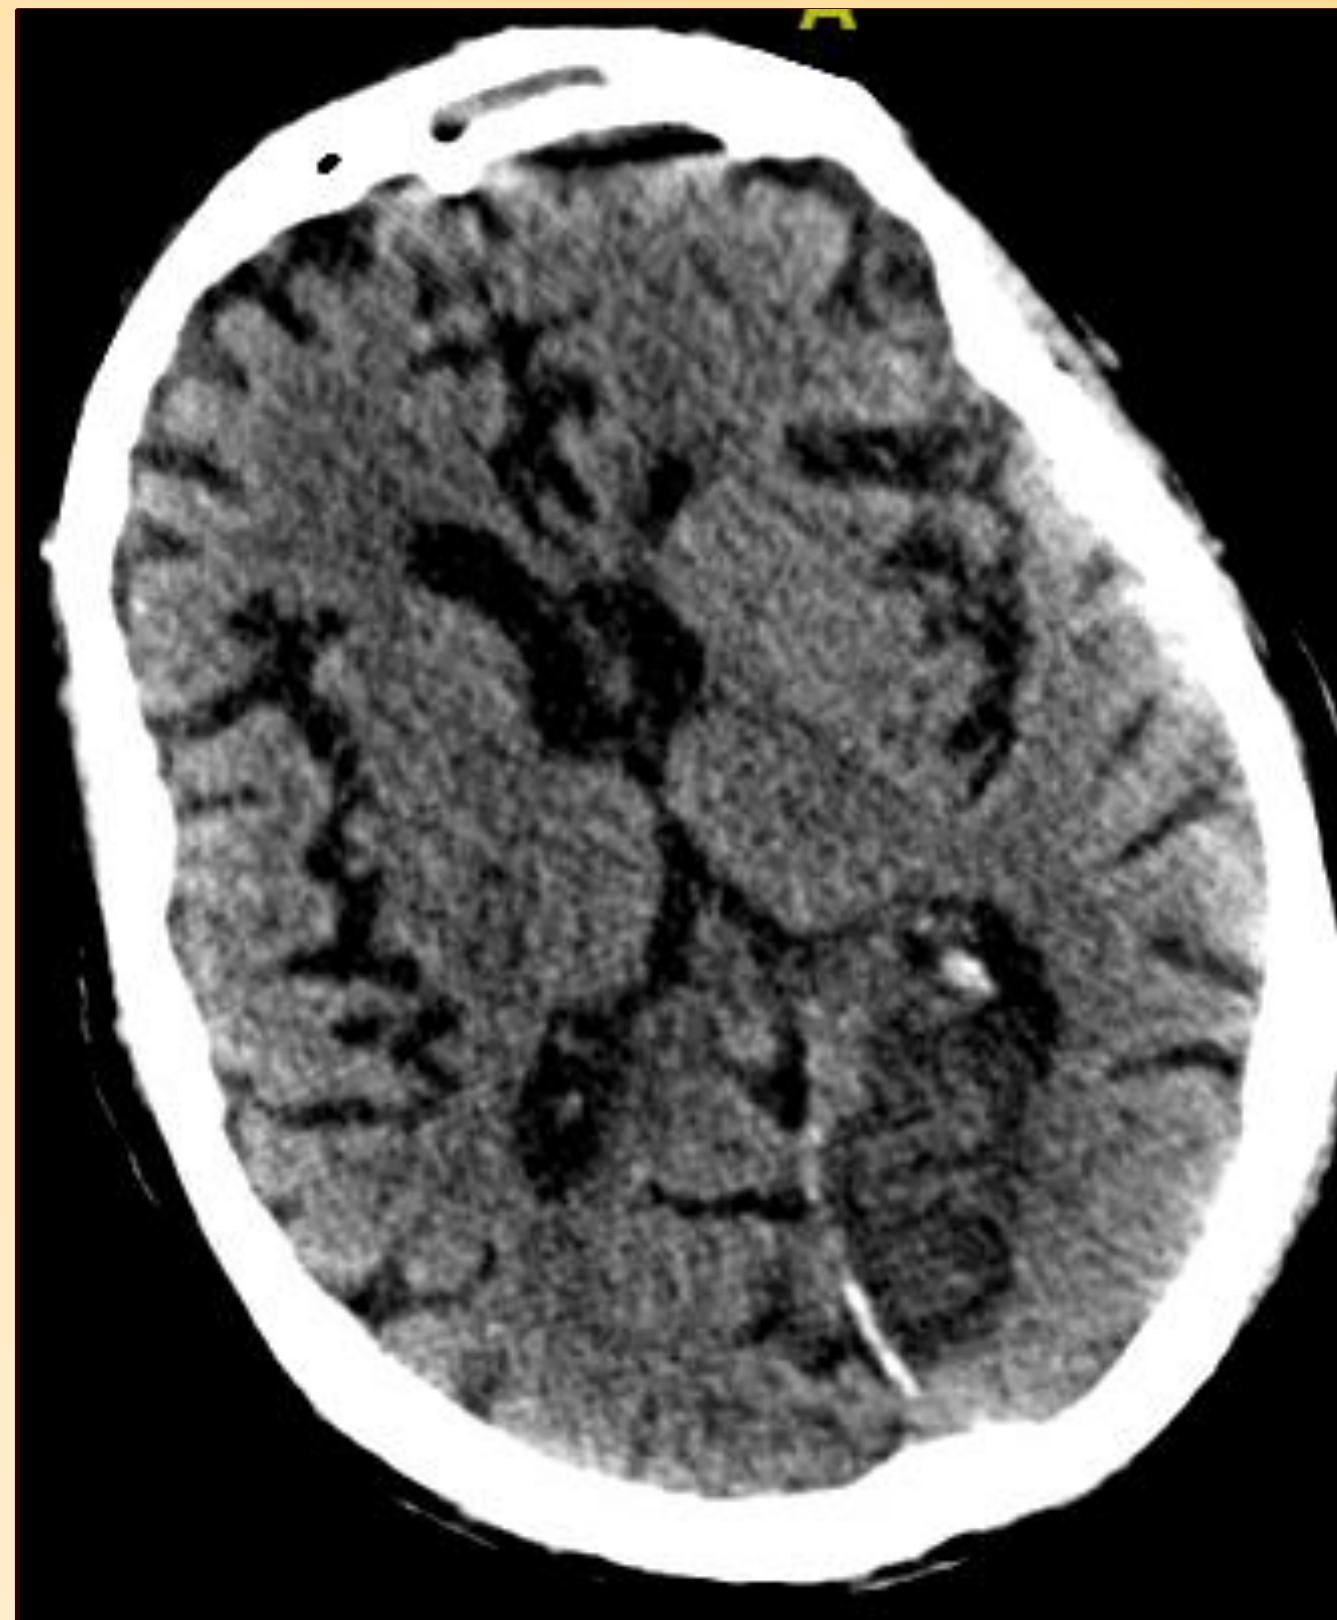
Patient's CT head imaging suggesting L occipital infarct
